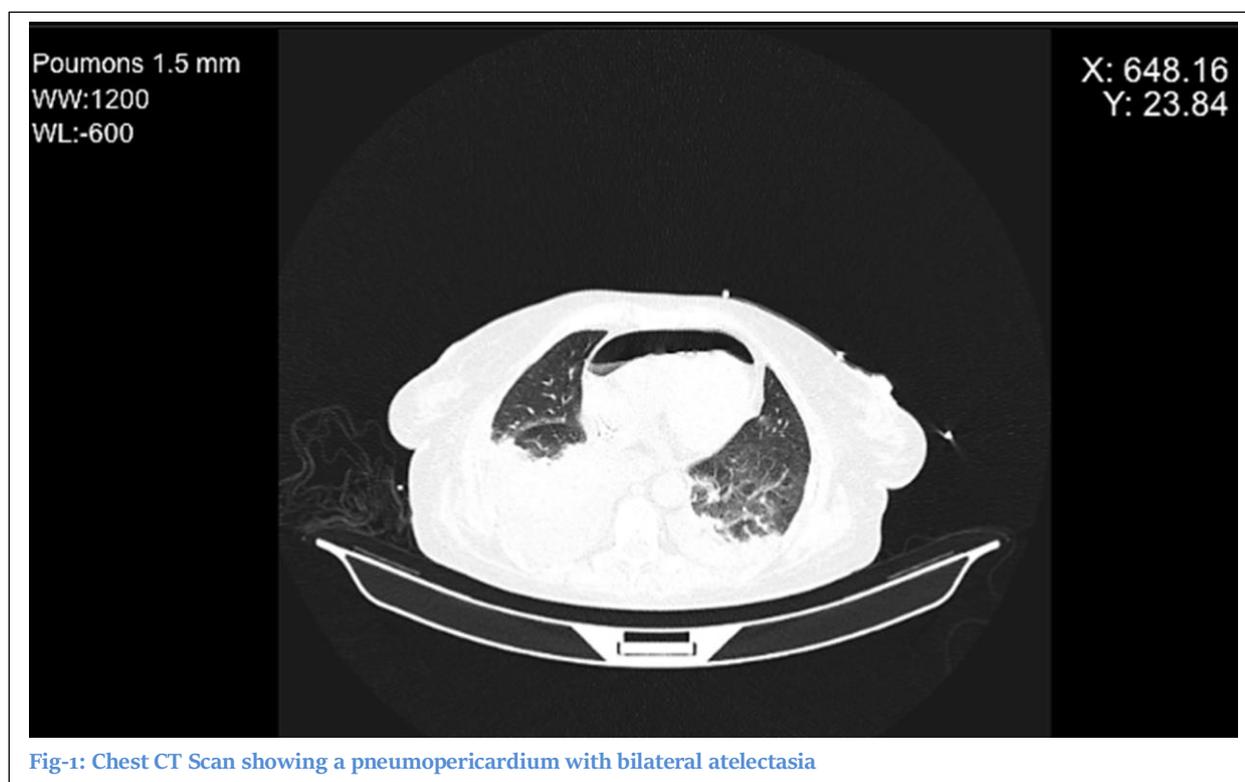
Chest CT Scan showing a pneumopericardium with bilateral atelectasia
